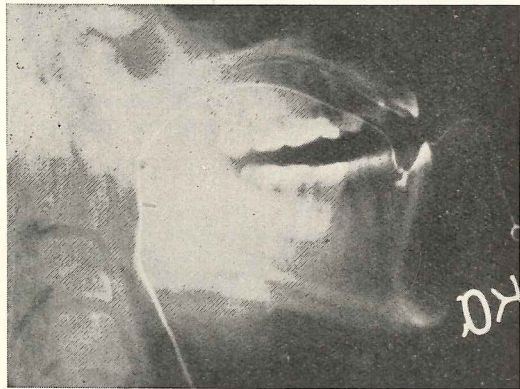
Vowel *a* in *cock* of the same Mid-West American subject as Fig. 1, subject allowed to speak normally. Caught in the sentence, *don't cock that gun it might go off*. X-ray exposure of 1/120 of a second.
